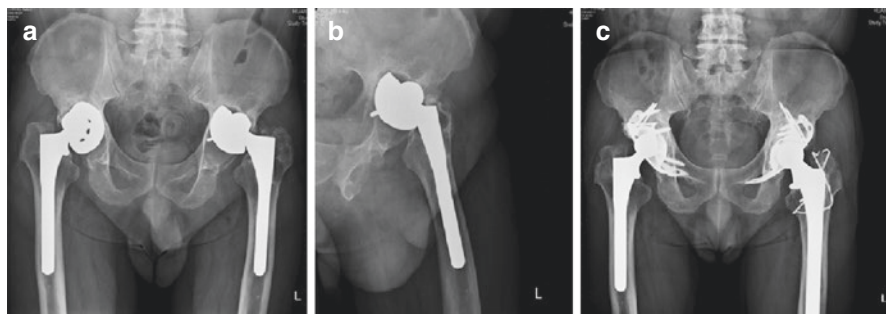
A 55-year-old man had bilateral aseptic loosening THA with Paprosky type IIIB acetabular defects (a and b). Radiographs after revision THA using anti-protrusion cage and bulk and morselized allografts. Reconstruction was at 7 years on right and 6 years on left side, showing optimum position of cages and cups (c). There was good healing of the grafts and no cage failure (these pictures were agreed by the patient for publication)
